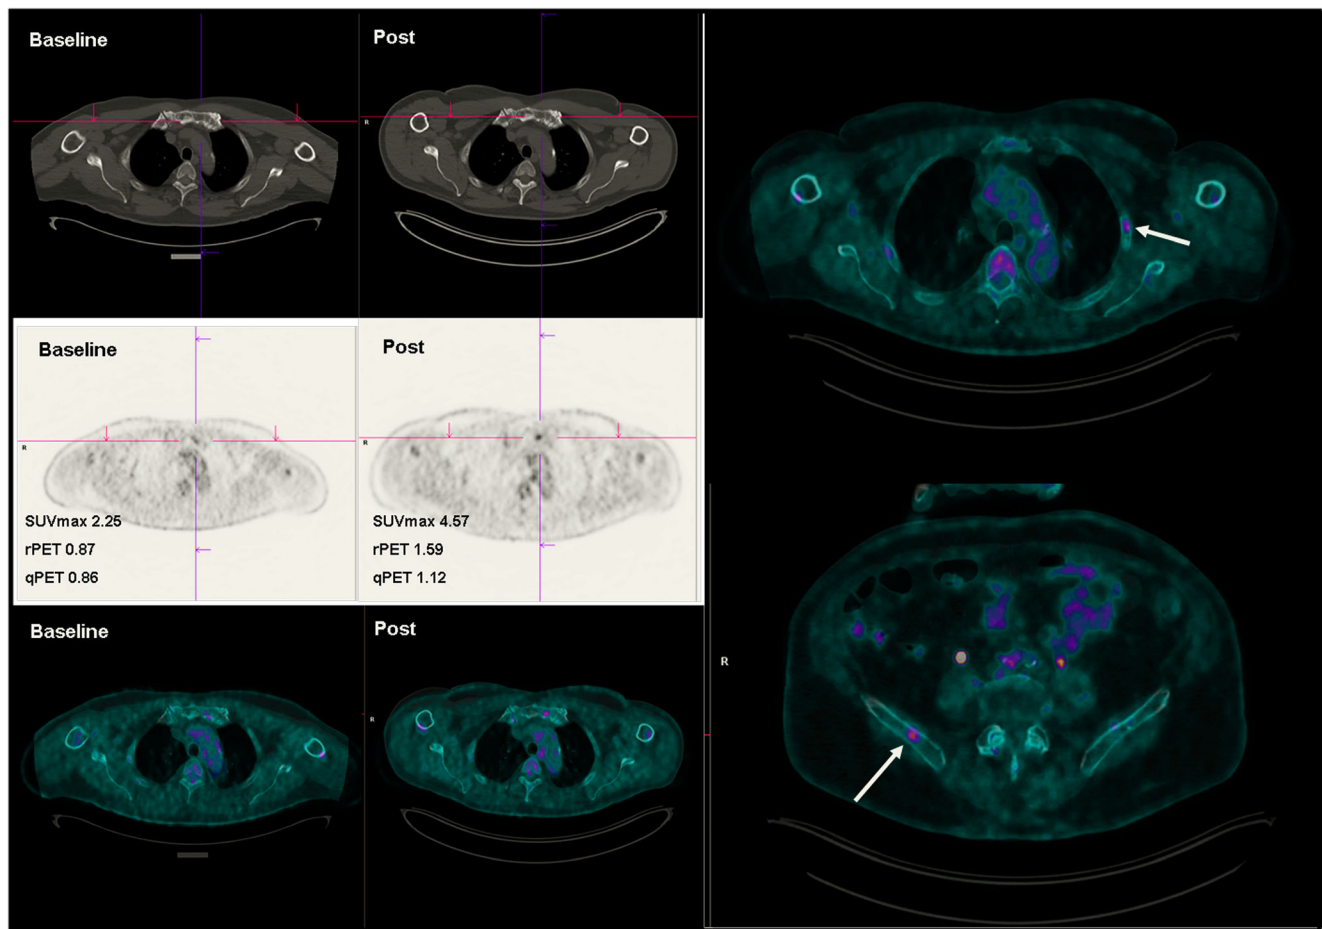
A 65-year-old male. Baseline PET-CT shows a single area of focal ^{18}F -FDG uptake on left sternum (SUVmax 2.25; rPET 0.87; qPET 0.86) in the absence of structural alterations; post-treatment PET-CT shows further increase in ^{18}F -FDG uptake at the same location (SUVmax 4.57; rPET 1.59; qPET 1.12). Δ values obtained (ΔSUVmax -2.32 ;
